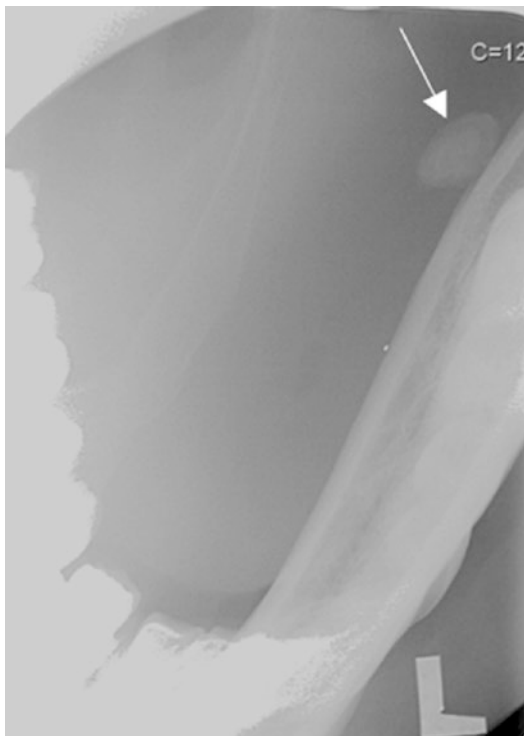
Lower 90-degree occlusal radiograph, showing a very large oblong calculus in the left floor of the mouth (white arrow). This is likely to be in the mid-third of the left submandibular duct
